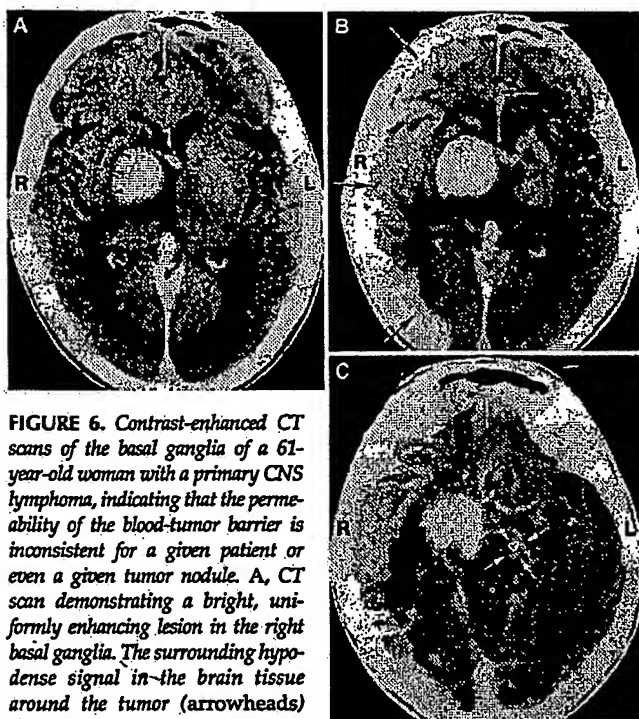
Contrast-enhanced CT scans of the basal ganglia of a 61-year-old woman with a primary CNS lymphoma, indicating that the permeability of the blood-tumor barrier is inconsistent for a given patient or even a given tumor nodule. A, CT scan demonstrating a bright, uniformly enhancing lesion in the right basal ganglia. The surrounding hypodense signal in the brain tissue around the tumor (arrowheads) should be noted (33). B, CT scan obtained after contrast agent administration. Contrast material was administered immediately after osmotic BBBD and CT scans were obtained 30 minutes after the first BBBD treatment, to confirm and assess the grade of BBBD. The patient underwent right internal carotid artery disruption in the anterior and middle cerebral artery distributions (arrows). Opening of the brain tissue around the tumor in the area of the peritumoral hypodense signal evident in the CT scan in A should be noted (33). C, CT scan obtained after BBBD in a patient with a right hemiparesis that was unexplained, because the only visible tumor was in the right cerebrum (A). BBBD the day after the CT scan in A extended into the posterior circulation via the posterior communicating artery. A left-side brainstem lesion not apparent in pre-BBBD imaging studies was noted. The right hemiparesis was thus attributable to a brainstem tumor (arrows) on the left that was not apparent on pre-BBBD MRI scans (intact BBB and no edema). Silbergeld and Chicoine (76) demonstrated tumor cells 4 cm from T2-weighted abnormalities among patients undergoing stereotactic biopsies.
